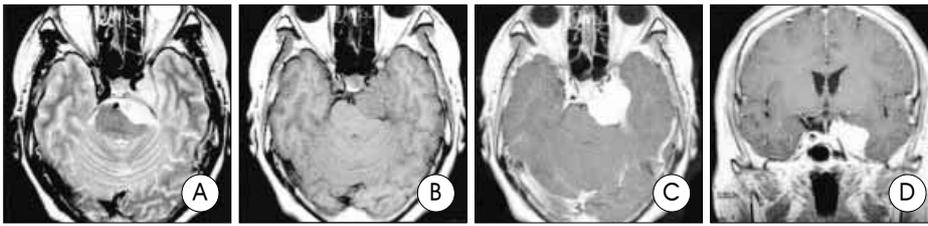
Preoperative magnetic resonance images. A: T2-weighted axial image reveals a hyperintense mass at the left cavernous sinus. This mass is compressing the brainstem and the left temporal lobe. It is associated with a minimal edema in the adjacent temporal lobe. B: T1-weighted axial image reveals a mass that is isointense to the brain cortex. C, D: Gadolinium-enhanced, the T1-weighted axial and the coronal images demonstrate a well-circumscribed, homogeneous mass with intense enhancement. The tumor is encasing the left internal carotid artery.
